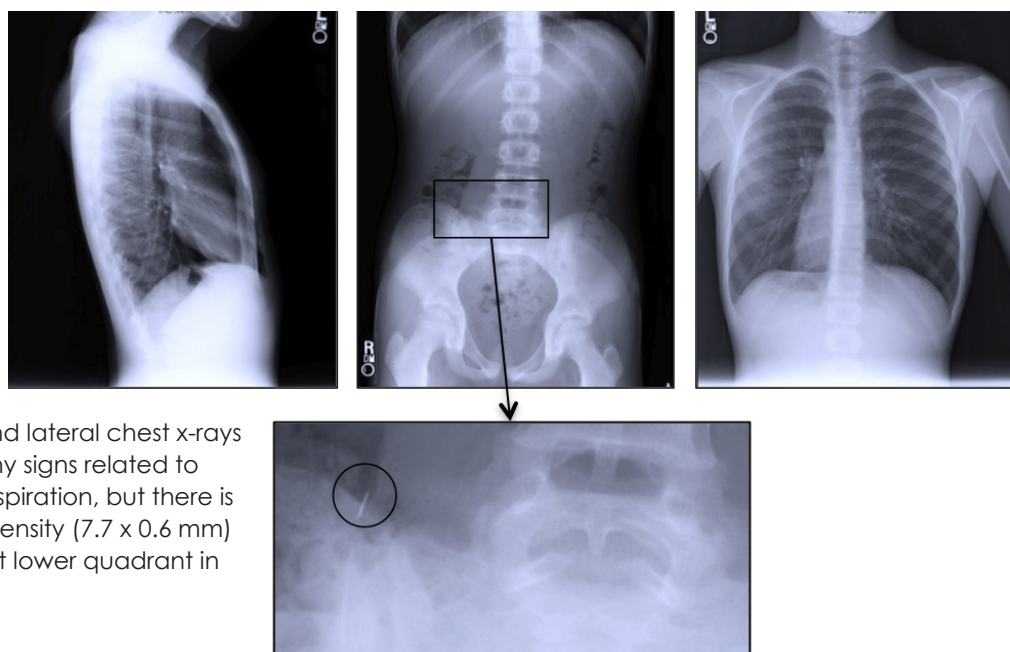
PA and lateral chest x-rays do not show any signs related to foreign body aspiration, but there is a linear radio density (7.7 x 0.6 mm) seen in the right lower quadrant in the KUB image.
